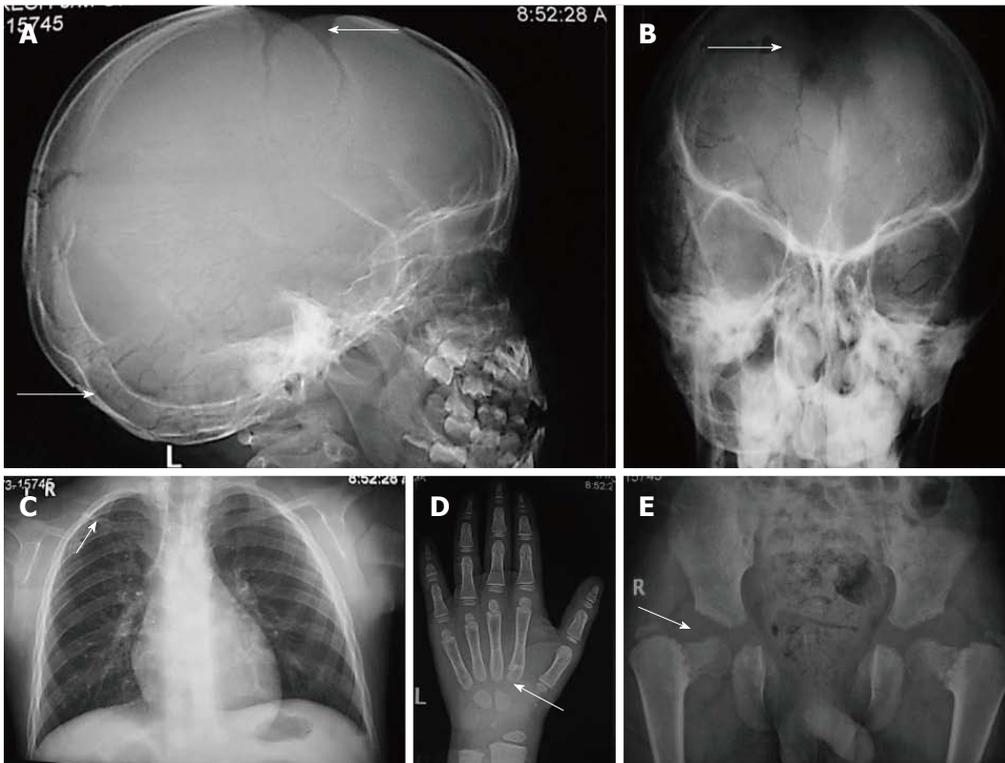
Cleidocranial dysplasia. Radiographs of skull (A, B) show open fontanelles and wormian bones (arrows, A) and hot cross bone appearance (arrow, B). Radiograph of chest(C) shows hypoplastic right clavicle (arrow). Radiograph of hand (D) shows elongated second digit with an accessory epiphyseal centre (arrow) Radiograph of pelvis (E) shows “chef-hat” shaped femoral heads (arrow) and widened pubis symphysis.
